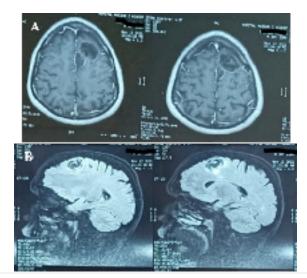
A: Axial T1-weighted MRI with contrast showing mixed signal with no enhancement B: Sagittal diffusion MRI showing a partial hyperintensity lesion.
